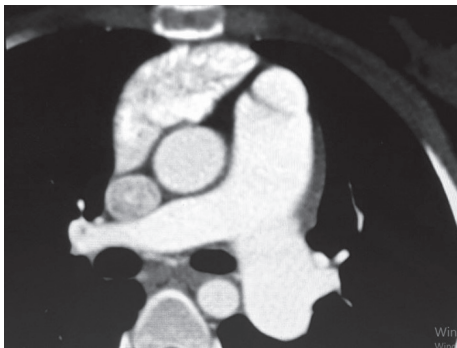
Pulmonary artery appearance on CT. Computed tomography showed the appearance of pulmonary conus and post stenotic dilatation in the left main pulmonary artery.
